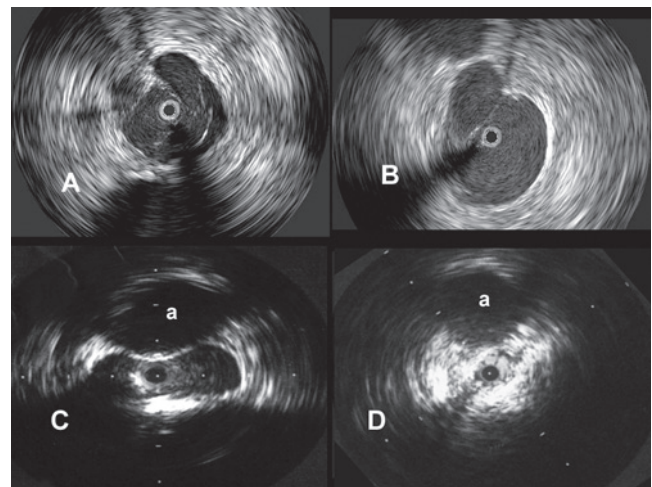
Images obtained by venous intravascular ultrasound (IVUS). A. Trabeculation with multiple lumina. B. Intraluminal septa. C. Moderate compression by the artery of a thin-walled vein. D. Severely compressed vein with sclerotic thick wall. The black circle inside the vein represents the inserted IVUS catheter and the a marks the artery.
